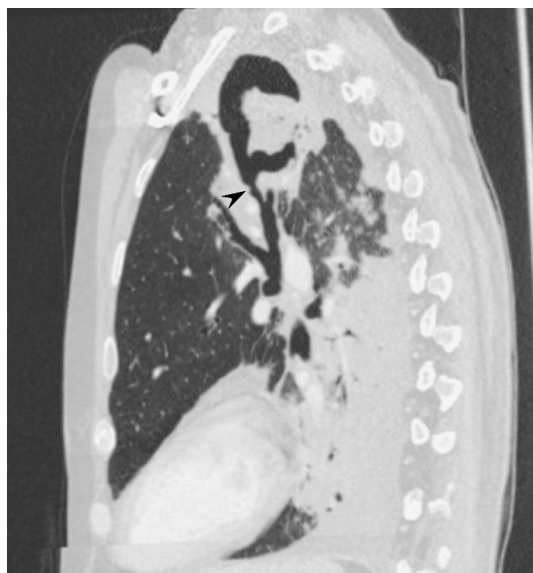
Sagittal CT image of a patient with solitary left upper lobe aspergilloma and left lower lobe consolidation. A broncho-cavitary communication is apparent (arrowhead).
